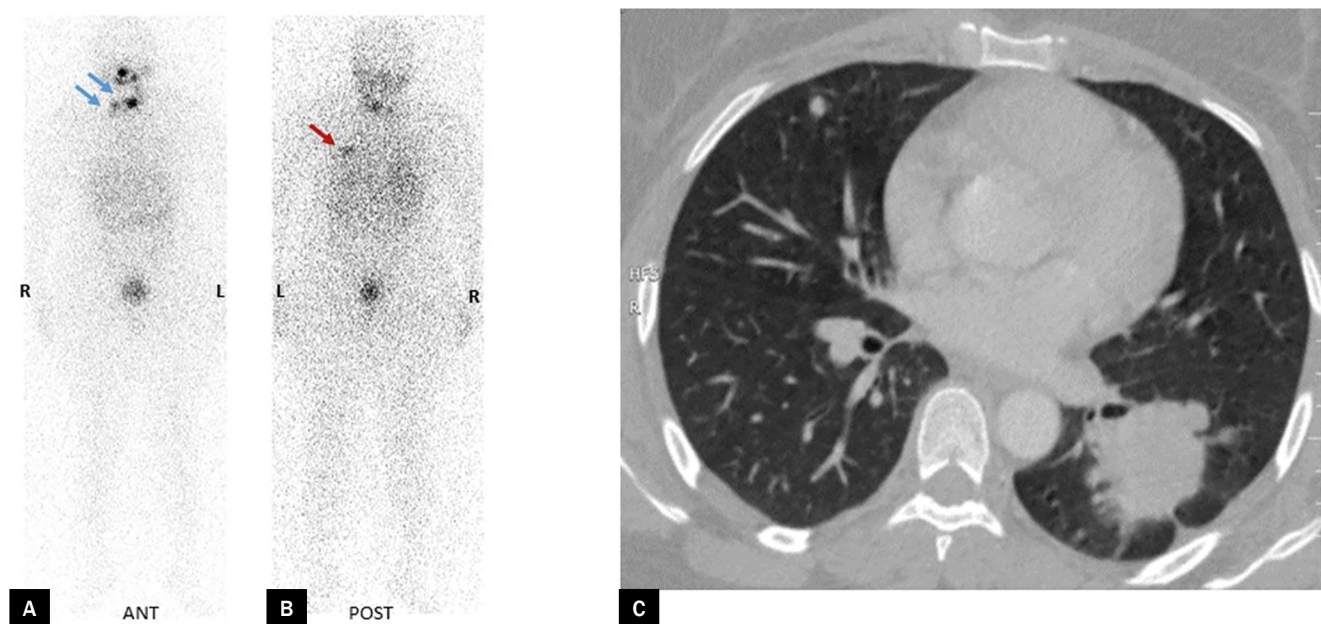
(A) Anterior view of post-radioiodine therapy whole body scan: increased uptake in the cervical region corresponding to thyroid remnants (blue arrows); (B) posterior view: increased uptake in the left side of the thorax (red arrow); (C) axial CT
